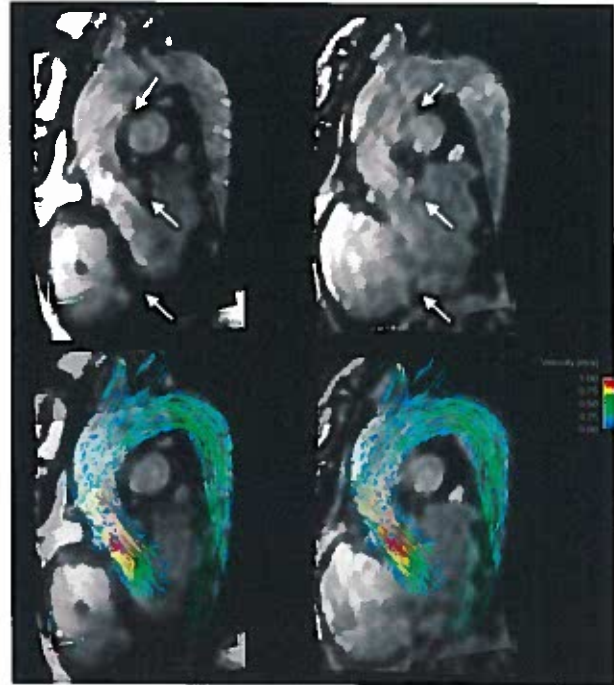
Systolic time-point from two movies (top: anatomy only, bottom: anatomy & 3D pathline visualization) depicting aorta, surrounding structures, and flow. Left: *k-t* 3D CINE bSSFP. Right: 4D flow MRI magnitude. Arrows indicate locations where the superior contrast of bSSFP has improved visualization of the blood-tissue interface.
